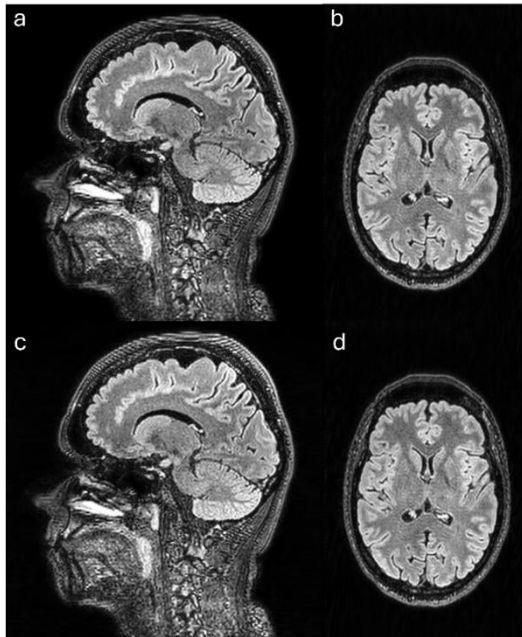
T2 FLAIR TSE of a mostly still subject. The non-corrected reconstruction (a/b) and the motion corrected reconstruction (c/d) show no significant difference.
